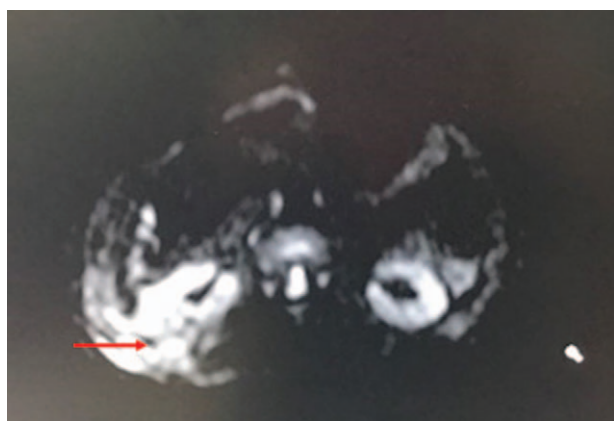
The whole-body DWI after the operation revealed abnormal signals in the upper part, adjacent to the right abdominal wall of the right renal level. DWI = diffusion weighted imaging.
